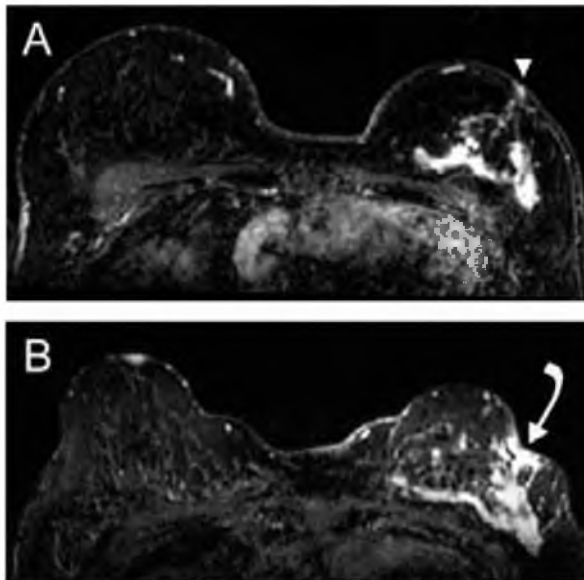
Twee subtractie beelden van de mammae van een 47 jaar oude vrouw die zich presenteerde met een T4 ILC in de linker mamma. Bij het initiële MRI onderzoek (A) is een grote diffuus groeiende tumor zichtbaar met betrokkenheid van de huid (pijlkop). De patiënte werd initieel behandeld met neoadjuvante chemotherapie. Op de controle MRI (B) is helaas zichtbaar dat de tumor hier niet goed op heeft gereageerd, maar in plaats daarvan is gegroeid (terwijl patiënte veel dunner is geworden). Verder is ook de ingroie in de huid duidelijk toegenomen (gebogen pijl). Als gevolg van deze bevindingen is een nood mastectomie uitgevoerd.
